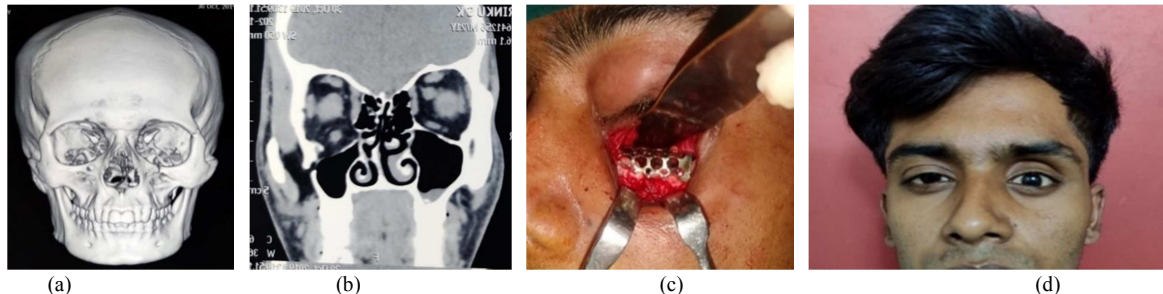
(a) and (b) CT skull and orbit images showing orbital floor fracture, (c) intra-operative image showing titanium mesh insertion, (d) postoperative image.
